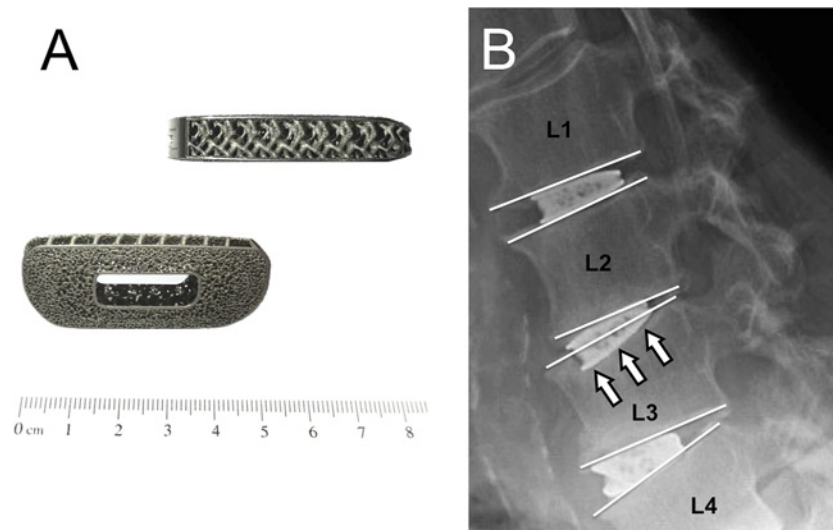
(A) Photograph of the 3D-printed titanium cage (Modulus; NuVasive, San Diego, CA). (B) Representative close-up view of a lateral postoperative radiograph demonstrating stand-alone 3D-printed titanium cages at L1/2, L2/3, and L3/4, with cage subsidence into the superior endplate of L3 (arrows). Endplates are exemplified by white lines.
